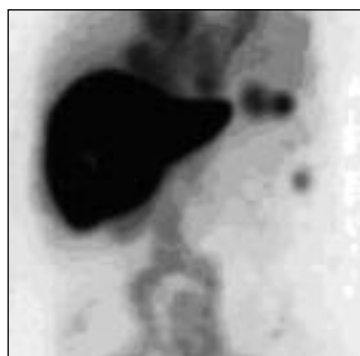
Tc-99m sulfur colloid scintigraphy
